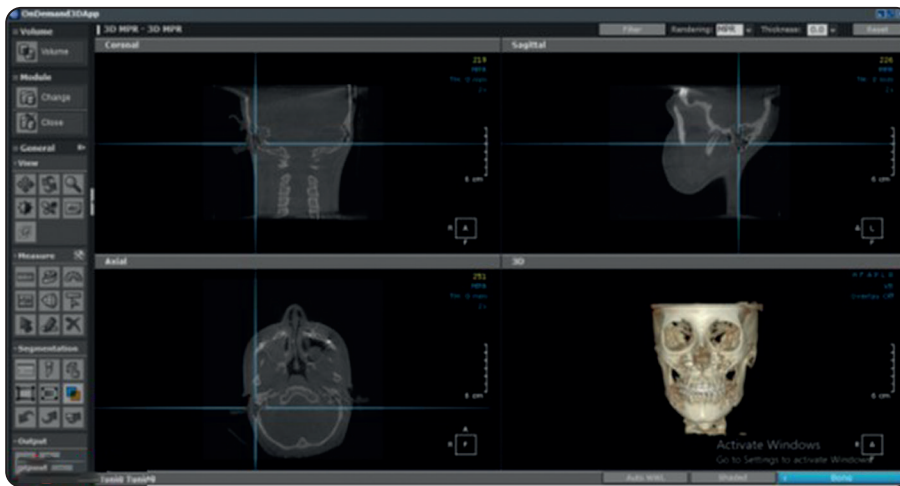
CBCT software showing image standardization, axial, sagittal, and coronal views were adjusted to display the mastoid process in its full size.
